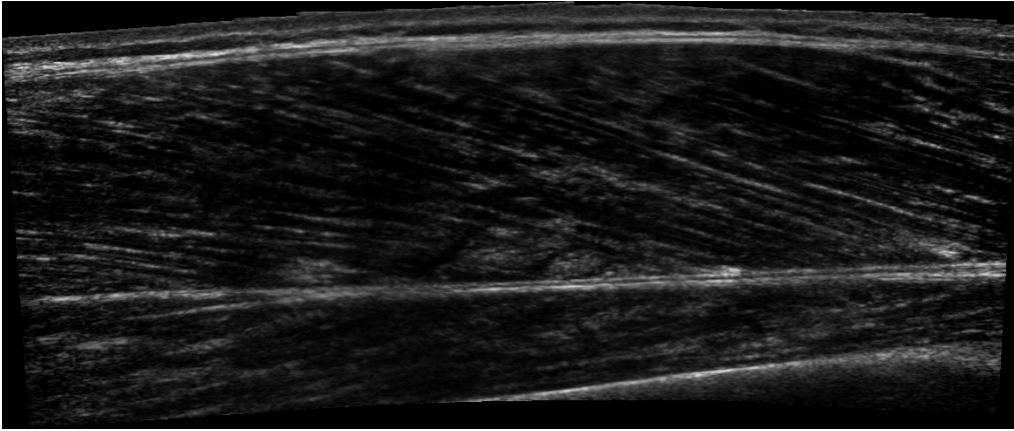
Ultrasound images stitched together to give an image of a larger part of the muscle.
